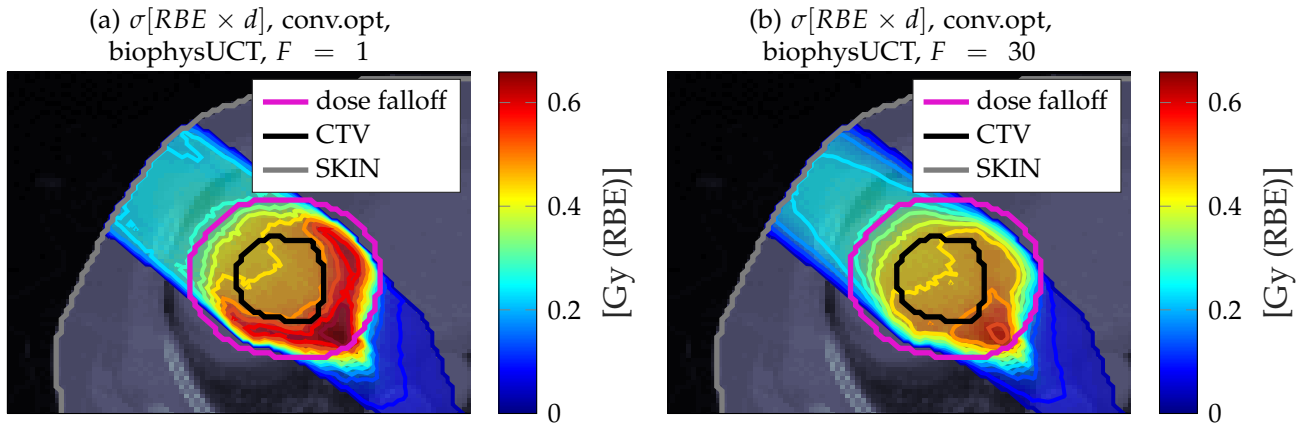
Transversal CT image of the liver case overlaid with transparent dose colorwash, solid contours and solid iso-dose lines to visualize the standard deviation of RBE weighted dose $\sigma[RBE \times d]$ after conventional optimization. Figure (a) assumes a single fraction in the calculation of $\sigma[RBE \times d]$ whereas Figure (b) presents the $\sigma[RBE \times d]$ assuming $F = 20$.
